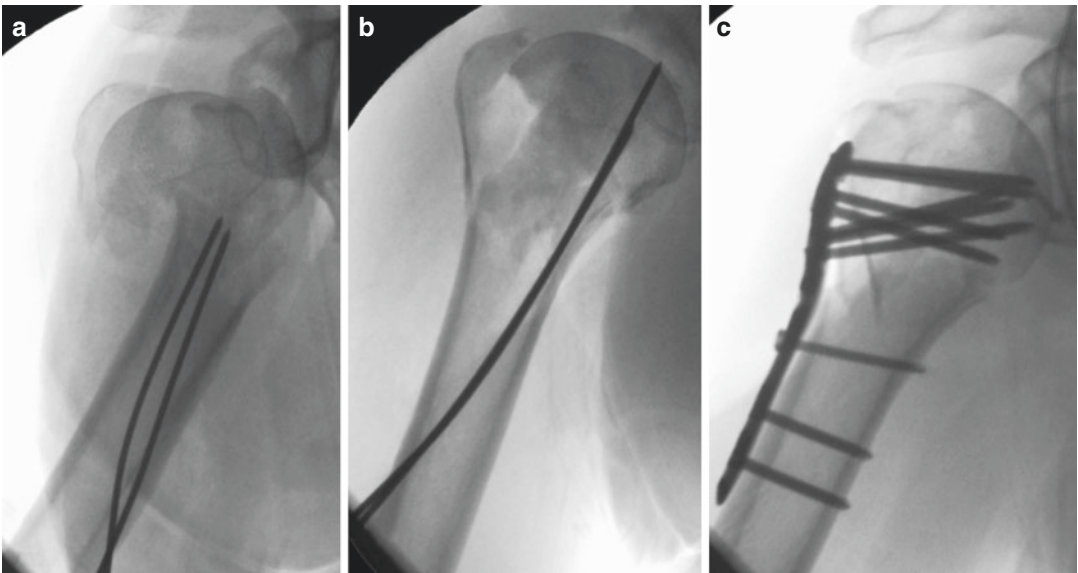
(a) Intraoperative radiograph of a 4-part fracture of a 45 y.o. male. The head fragment has been put into a valgus position after the placement of two intramedullary K-wires. (b) From the valgus position, the head has been
